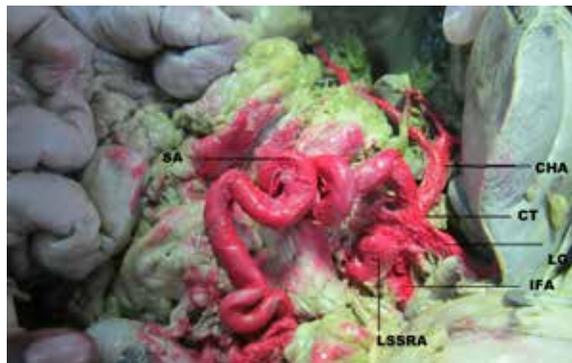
shows coeliac trunk giving 5 branches namely left gastric, inferior phrenic, left superior supra renal, splenic and common hepatic. (CT- coeliac trunk, CHA- common hepatic artery, LG-left gastric, IFA-inferior phrenic artery, LSSRA-left superior supra renal artery, SA-splenic artery)
